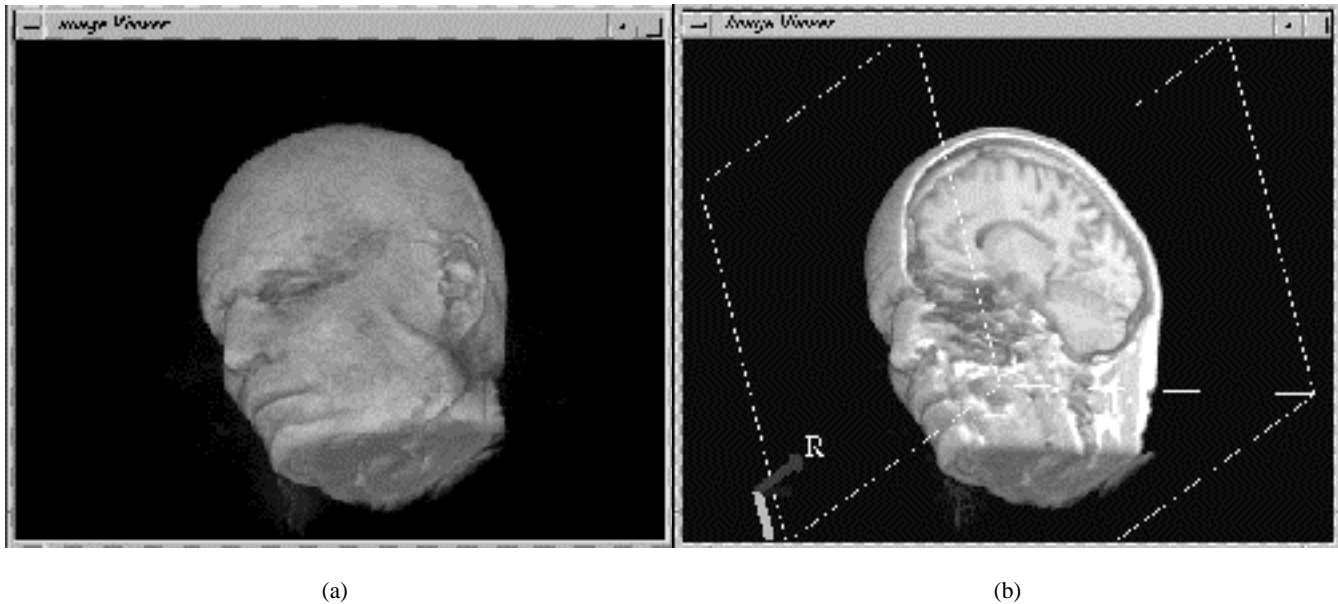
(a) Rendered MRI volume (b) with surface structure removed by using a clipped plane
